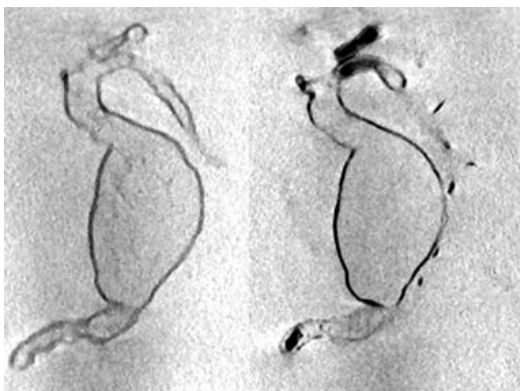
CT scanning of the 3D printed abdominal aortic aneurysm models with model immersed in a plastic container filled with contrast medium.
